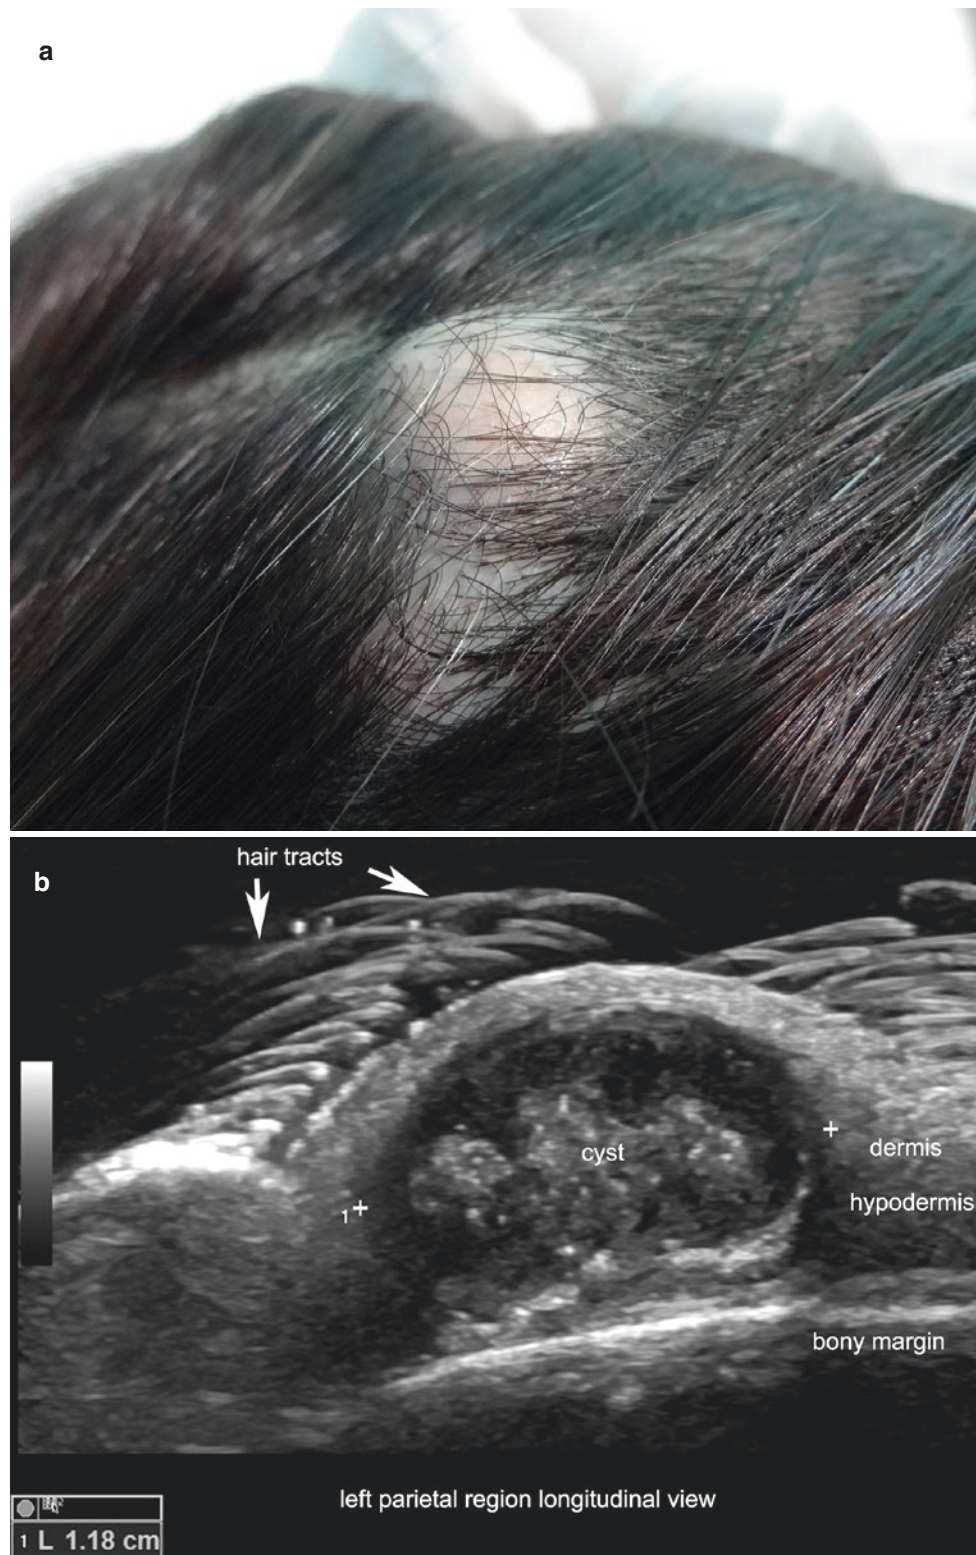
Trichilemmal cyst. (a) Clinical image. (b) Ultrasound (greyscale, longitudinal view, left parietal region) shows an 11.8-mm, well-defined, oval-shaped, anechoic structure with prominent echoes
